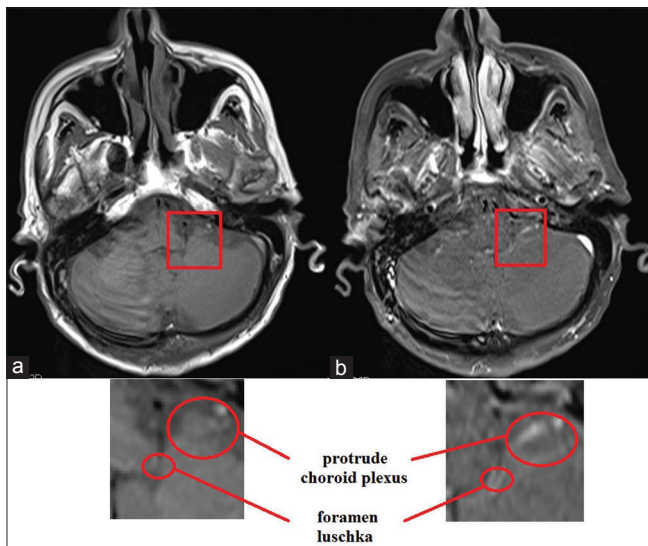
Preoperative T1 axial magnetic resonance images, both non-contrast enhanced (a) and contrast enhanced (b) images, showing choroid plexus tissue protruding from foramen of Luschka
